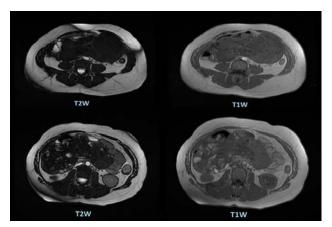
Magnetic resonance imaging scan. Transversal T2W and T1W images. Massive tumor formation stretching from the ascending colon to the anterior abdominal wall bearing a T2W hypointense signal with relative T1W isointensity.
